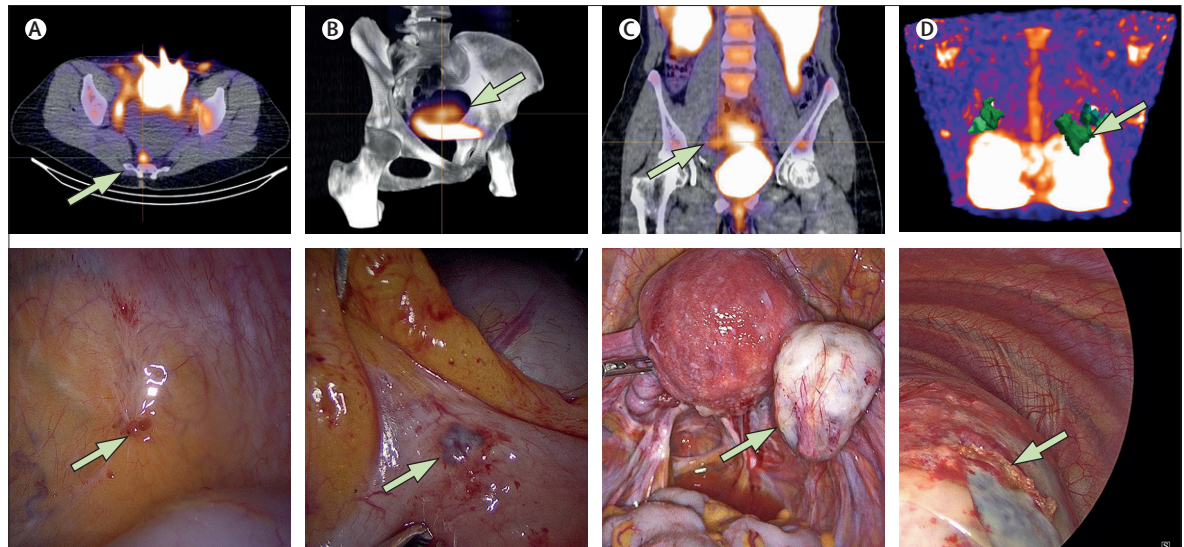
Representative single-photon-emission CT-CT detection and matching surgical images of superficial peritoneal endometriosis (A), deep endometriosis (B), ovarian endometrioma (C), and thoracic endometriosis (D) from four different participants. Arrows indicate region of interest. Thorax images were taken using only single-photon-emission CT imaging.
